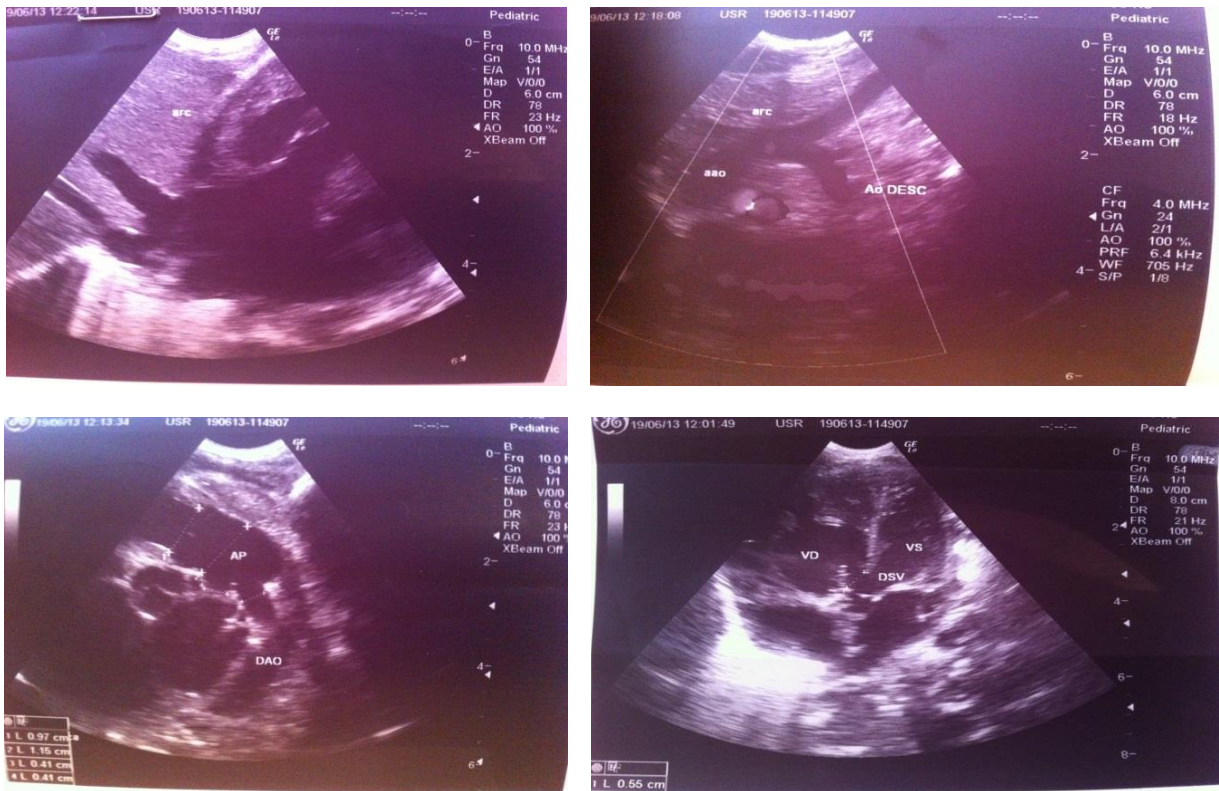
Echocardiography shows interrupted aortic arch, dilated pulmonary artery, wide ventricular septal defect.
